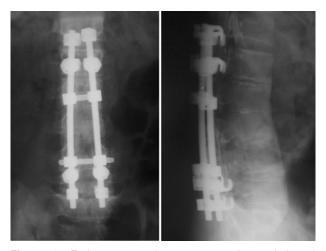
Early postoperative anteroposterior and lateral radiographic views. Bilateral posterolateral fusion of L1 to L5 was performed.
